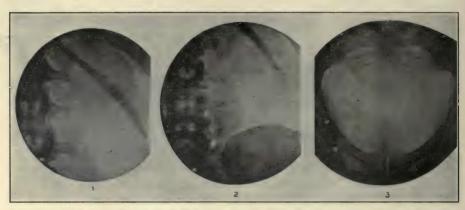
Necessary Views for Complete X-Ray Examination of the Urinary Tract (after Haenisch). 1. Immediate kidney region. Note normal kidney outline, distinct psoas shadow, transverse processes of vertebræ and 11th and 12th rib. 2. Ureteral area from second lumbar vertebræ to crest of ilium. 3. The lower ureteral and bladder area.
